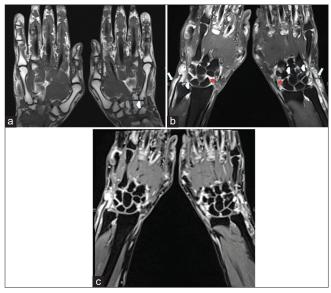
Magnetic resonance imaging of both hands demonstrates diffuse tenosynovial soft-tissue thickening and hyperintense inflammatory changes involving all extensor and flexor tendons, particularly in bilateral extensor carpi ulnaris tendon sheath (arrow) and shows intense contrast enhancement in the postcontrast examination, the tendons themselves appear normal. There is marked pannus and inflammation (*) around the wrist articulations and erosions in the distal ulna, right 3rd, and 4th metacarpal bases, left hamatum and 4th metacarpal bone (arrowheads). (a) Precontrast coronal T1-weighted magnetic resonance image, (b) Coronal T2-weighted fat-saturated magnetic resonance image, (c) Postcontrast coronal T1-weighted fat-saturated magnetic resonance image
